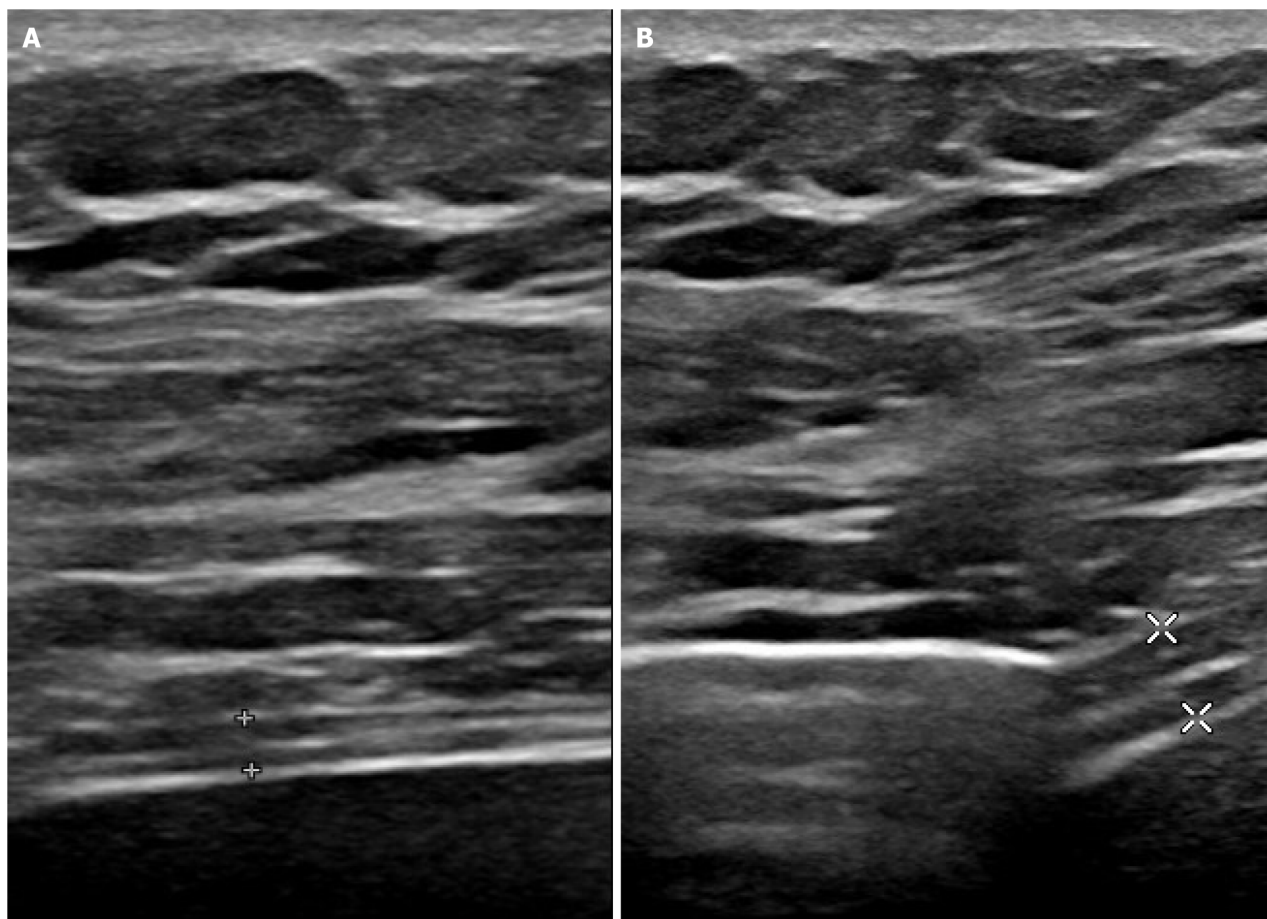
Measurement of thickening fraction using B mode ultrasonography. A: End of expiration (1.7 mm); B: End of maximal inspiration (3.8 mm). Measurement of diaphragm thickness at expiration (1.7 mm), and at deep inspiration (3.8 mm) – here thickening fraction = $(3.8 - 1.7) / 1.7 = 123\%$.
